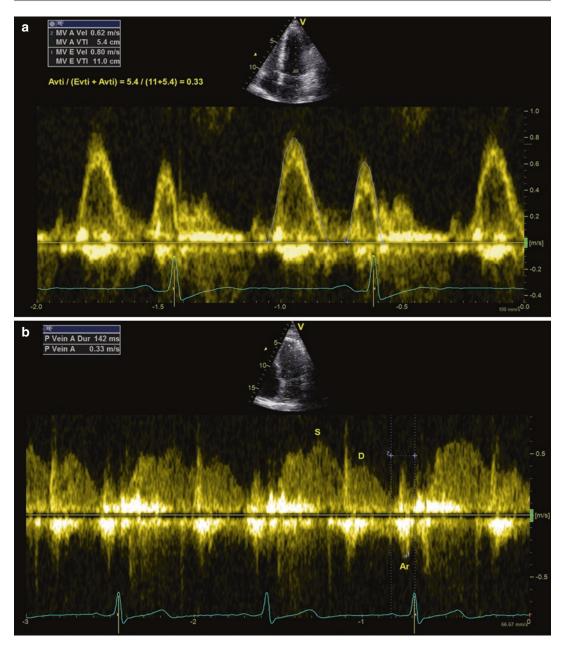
Assessment of atrial function by transmitral and pulmonary inflow spectral Doppler tracings. The relative contribution of LA booster pump function is assessed by the ratio of the mitral A wave VTI to the total diastolic
